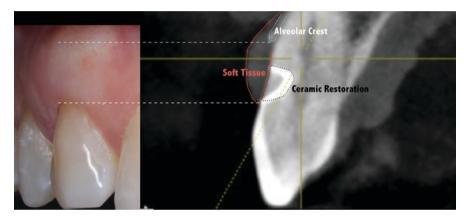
At 60 month follow-up, cone beam computed tomography of tooth 1.3 was requested for imaging analysis
